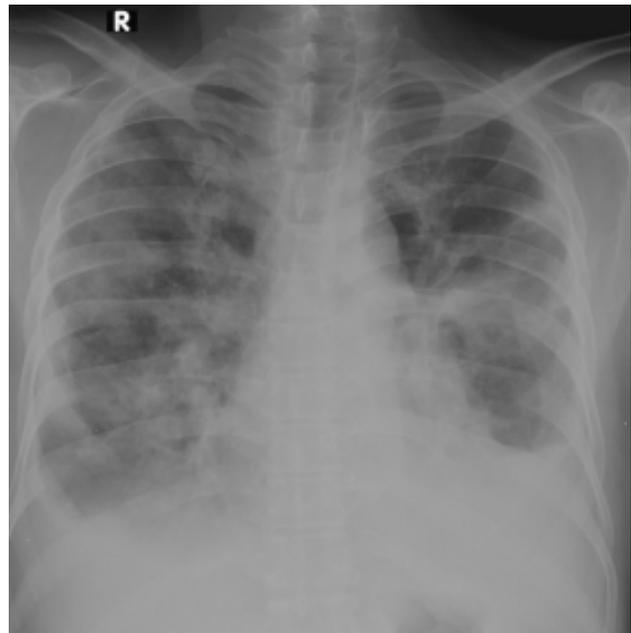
Chest radiograph PA view, showing perihilar reticular and patchy acinar shadows, mild volume loss on left side and bilateral mild pleural effusion.
